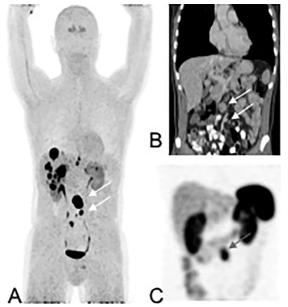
Patient with liver and mesenteric lymph node metastases from a small bowel neuroendocrine tumor grade 1. A. Maximum intensity projection of whole body <sup>18</sup>F-DOPA PET showing multiple liver lesions and metastases in the mesenterium. Physiologic uptake is seen in the striata. Physiological excretion is via the kidneys and ureters to the bladder. B. Abdominal CT showing large and smaller (white arrows) malignant mesenteric lymph nodes. C. On the 111 In-DTPA-octreotide SPECT scan 24 h after injection only the large mesenteric lymph node could be visualized (grey arrow).
